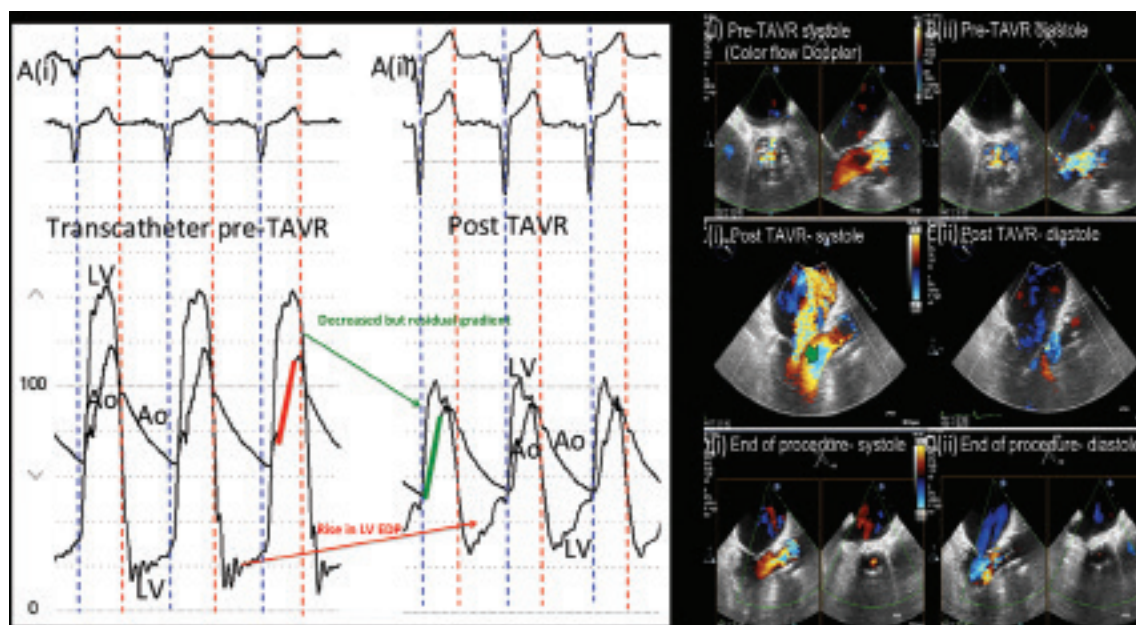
Hypotension after TAVR. Changes in aortic stenosis hemodynamics immediately after TAVR (left panel) show a reduced LV-aortic (Ao) gradient, but with rapid rise in LVEDP with equilibration of the Ao diastolic pressure. By the tracing alone, one cannot differentiate acute aortic regurgitation (AR) from possible mitral regurgitation (MR). Echocardiography (right panel) showed mitral regurgitation after TAVR by systolic anterior motion of the anterior leaflet (AMVL). Color flow Doppler findings at baseline top right, post TAVR (middle right), and at the end of the procedure, in systole (bottom right, i) and diastole (bottom right, ii). Relief of aortic valve stenosis increased contractility resulting in systolic anterior motion of the AMVL and severe mitral regurgitation. Fluid loading relieved the MR.
